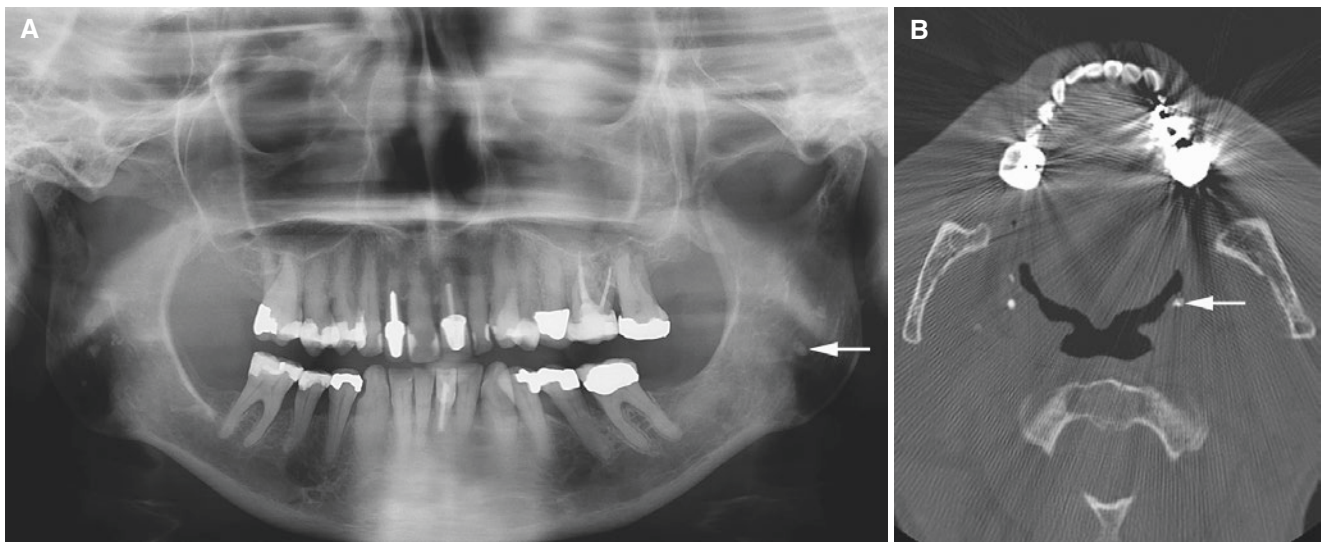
Calcification in palatine tonsil; 65-year-old female with incidental finding. (A) Panoramic view and (B) Axial CT image show small calcification (*arrow*), bilaterally
